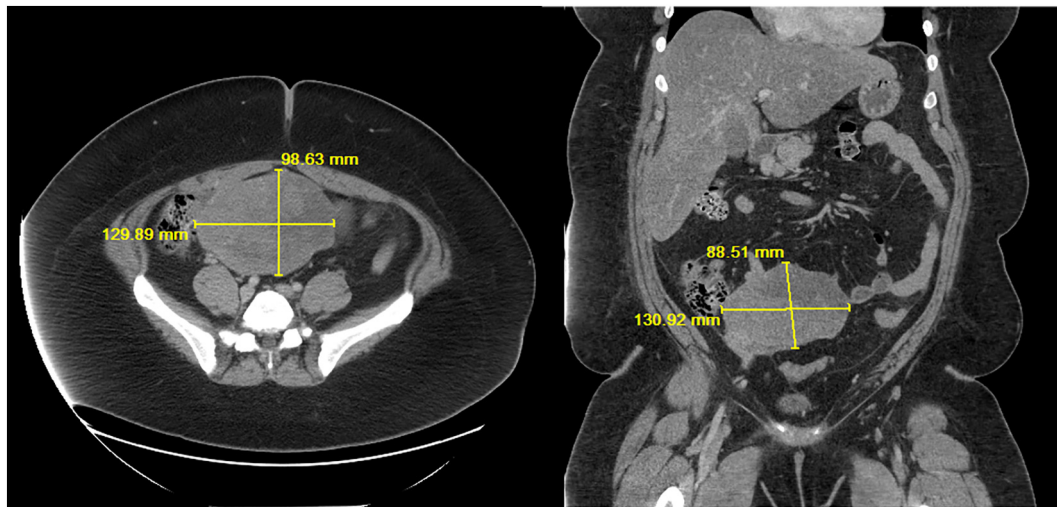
Pre-therapy axial and coronal computed tomography (CT) imaging. Abdominal and pelvic CT scan with IV contrast at diagnosis revealed a $13 \times 9.9 \times 8.9$ cm heterogeneous mass with well circumscribed margins. No mass was identified on a CT scan performed 21 months earlier. Small mesenteric lymph nodes noted on the prior CT scan were unchanged on the diagnostic scan. Moderate diffuse fatty infiltration of the liver was also noted.
